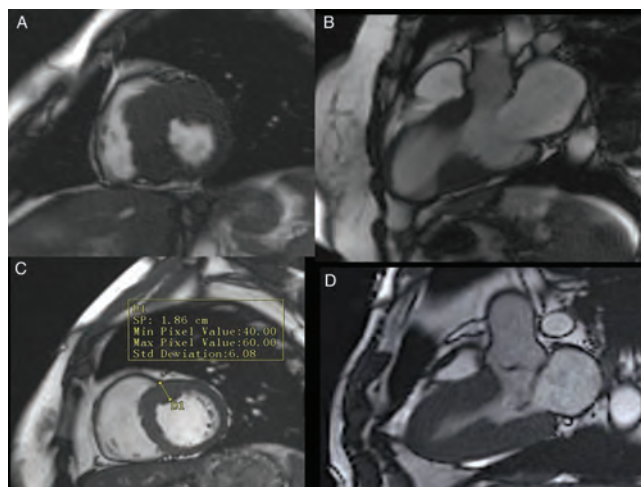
Cardiac MR in HCM patients. Cine CMR-SSFP in different HCM patients. (A) Basal short-axis view, asymmetric LVH with lateral wall sparing. (B) Three-chamber view, mid-ventricular hypertrophy of the medial segments of the posterior wall and anterior interventricular septum. (C) short-axis view, LVH localized in the anteroseptal wall (18 mm), undetected by echocardiography. (D) Three-chamber view, systolic phase. (Reprinted with permission from Cardim et al. [38]).
